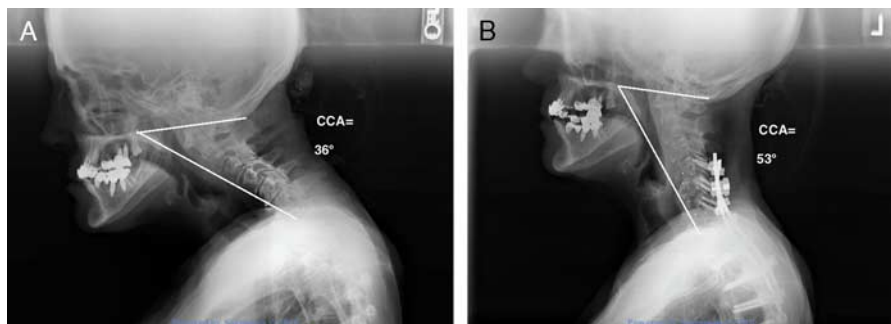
Cervical radiograph depicting the craniocervical angle (CCA) on preoperative (A) and postoperative (B) radiographs after deformity correction. CCA accounts for both cervical sagittal inclination and upper cervical compensation and is defined as the angle of the line from the center of C7 to the posterior corner of the hard palate and McGregor's line (the line from the posterior corner of the hard palate to the most caudal point of the occiput).
